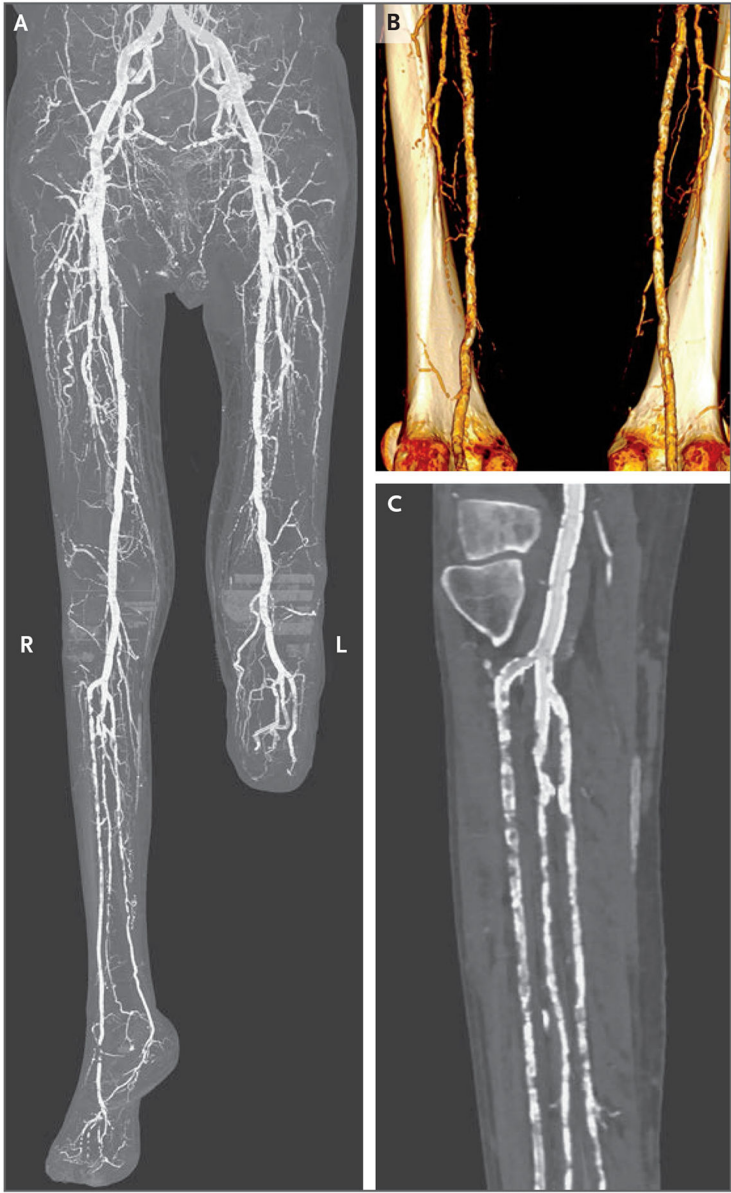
CT Angiography with Runoff. Panel A shows a two-dimensional maximum-intensity projection image of both legs (after the left below-knee amputation). Panel B shows a three-dimensional reconstruction of both superficial femoral arteries. Panel C shows a two-dimensional image of the right popliteal and below-knee arteries. L denotes left, and R right.
